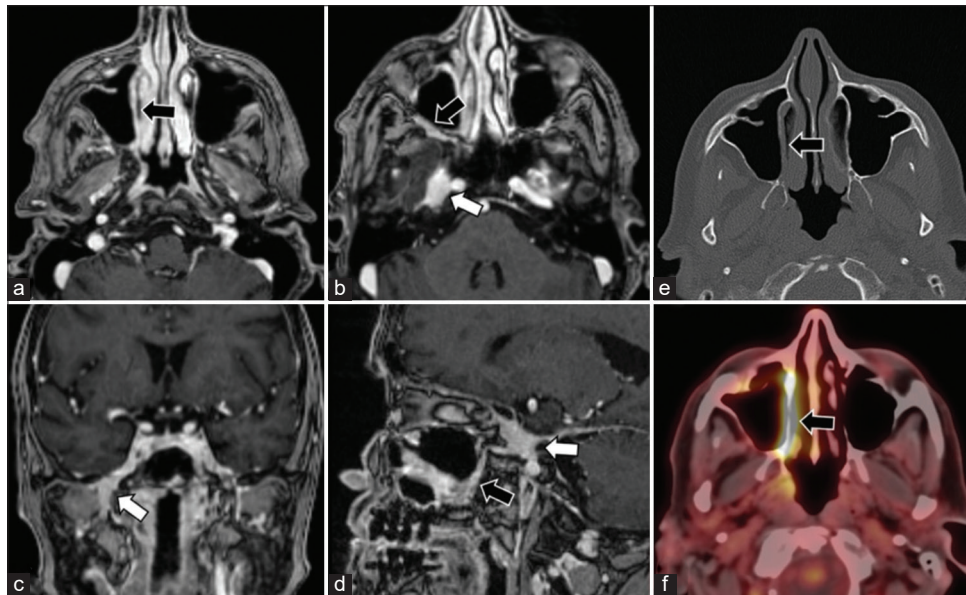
Sinonasal diffuse large B cell lymphoma in a 74-year-old female. Axial 3D T1 MPRAGE after IV gadolinium administration (a and b) showed asymmetric submucosal enhancement along the medial wall of the right maxillary antrum and within the right retromaxillary space (black arrows). Asymmetric thickening and mass like enhancement of the right V3 nerve at the level of right foramen ovale was noted (white arrow). Coronal (c), and sagittal (d) 3D T1 MPRAGE after IV gadolinium administration confirmed the abnormal thickening and mass enhancement at the right Meckle's cave, right foramen ovale, right masticator space and right retromaxillary spaces (arrows). Axial high-resolution non-contrast CT of the sinuses (e) revealed demineralization and lytic changes of the right maxillary medial wall, corresponding to abnormal enhancement on MRI. Axial fused PET/CT image at the level of maxillary antra (f) confirmed hypermetabolic mass along the right maxillary medial wall.
